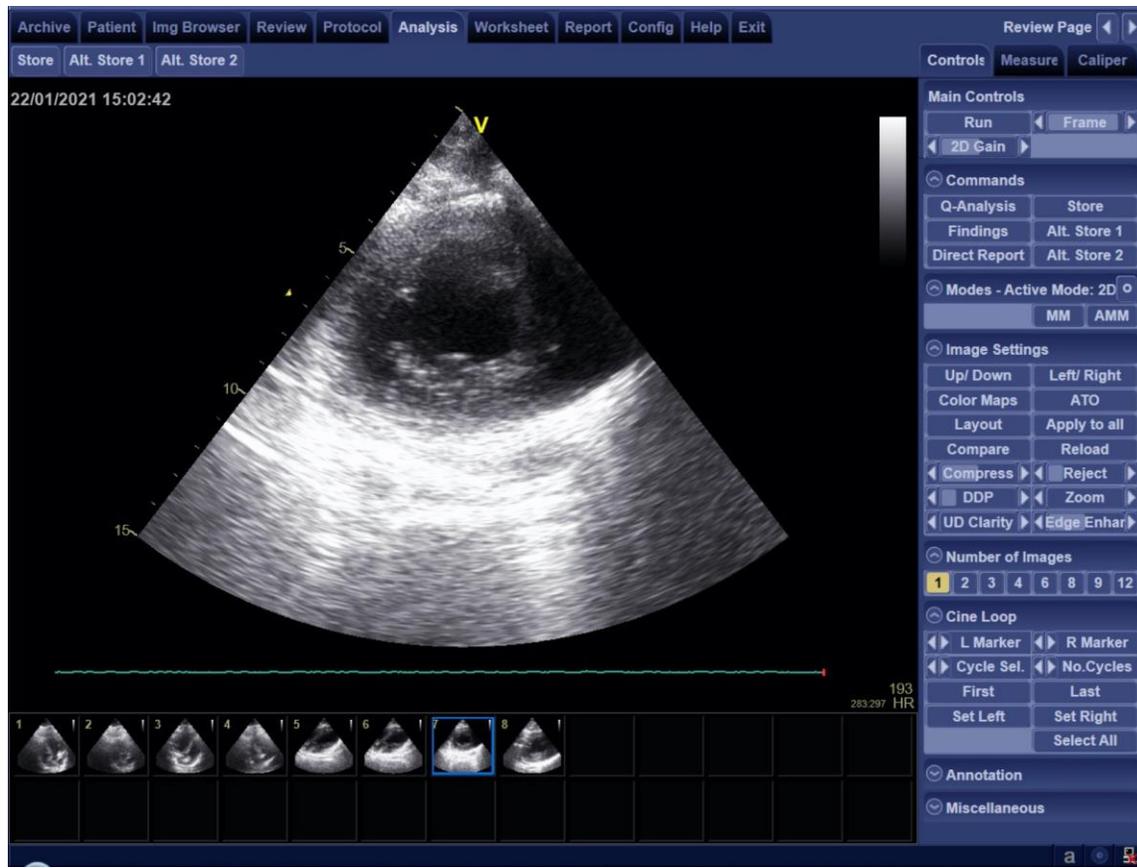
Parasternal short axis (PSAX) of the Left Ventricle (LV), representative of the medial-lateral site of Left Ventricle Chest Compression (LVCC).
